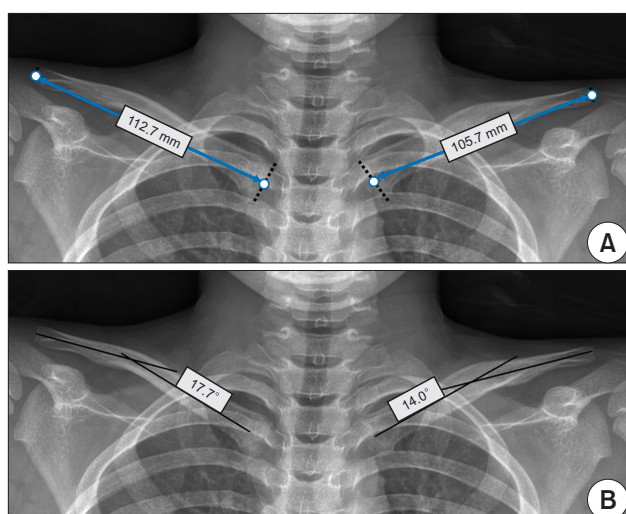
Radiological evaluation. (A) Measurement of the clavicle length on the anteroposterior (AP) X-ray of the clavicle: clavicle length was defined as the length of the line connecting the midpoint of the lateral border of the clavicle and the midpoint of the medial border. Shortening was calculated by subtracting the length of the fractured clavicle from the length of the uninjured clavicle. (B) Measurement of angulation on the AP image of the clavicle: angulation was defined as the angle between the long axes of the medial and lateral diaphysis. Angulation was calculated by subtracting the angle of the fractured clavicle from the angle of the uninjured clavicle.
